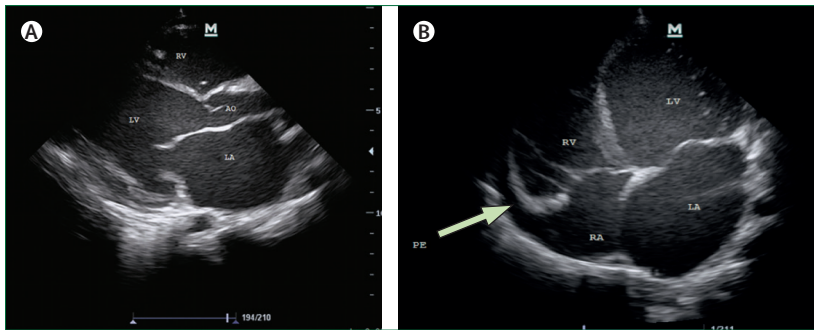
Echocardiogram of a girl aged 12 years with HIV (A) Parasternal long axis view. (B) Apical four-chamber view showing pericardial effusion. AO=aorta. LA=left atrium. LV=left ventricle. RA=right atrium. RV=right ventricle. PE=pericardial effusion.
